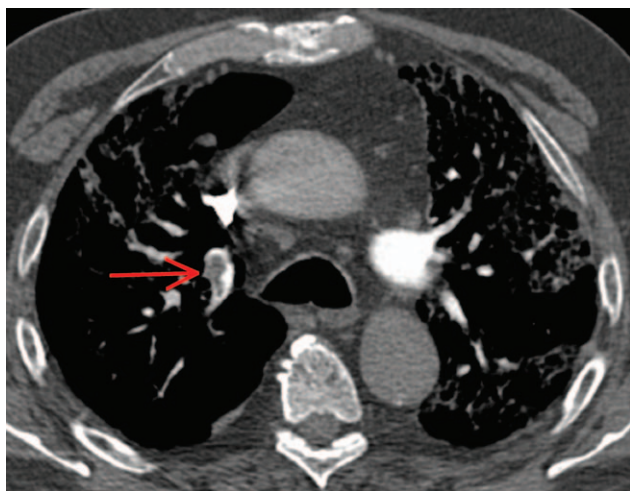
Axial CT pulmonary angiography showing lobar thromboembolism, with a low-density thrombus (red arrow), less frequently observed in COVID-19 patients receiving low-molecular-weight heparin at prophylactic dosage. COVID-19=coronavirus disease 2019; CT=computed tomography.
